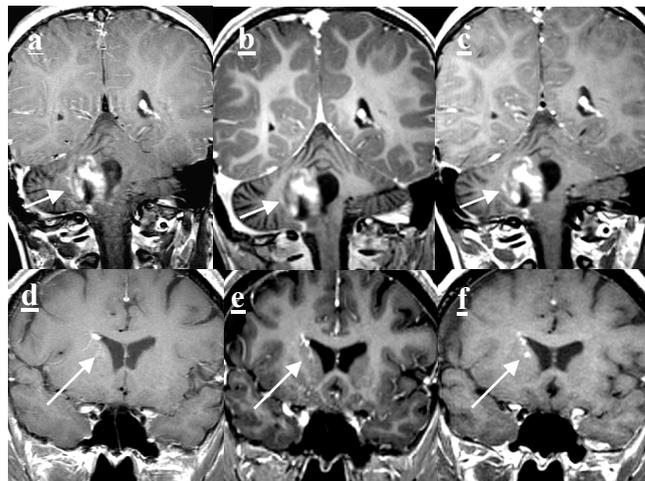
a, d: 2D FSE T1-weighted; b, e: BRAVO; c, f: T1 CUBE. TOP ROW: The 2D FSE T1W and T1 CUBE images give superior depiction of the margins of this enhancing cerebellar tumor, in part because of greater CNR of contrast-enhancing tumor to adjacent cerebellar white matter. BOTTOM ROW: A channel of this venous angioma is best appreciated with the T1 CUBE, because of greater CNR relative to BRAVO and probably because of smaller section thickness relative to 2D FSE T1W.
